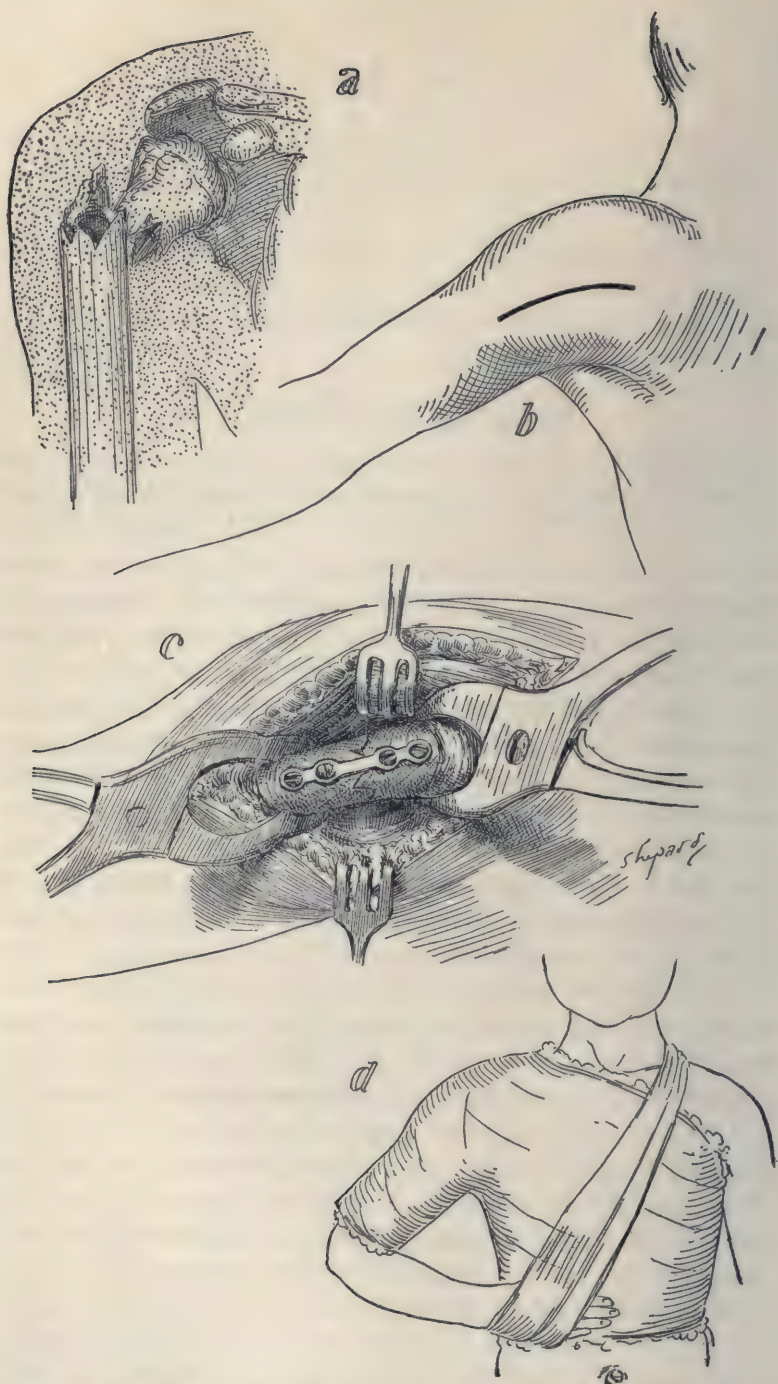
Fracture of upper end of humerus: *a*, x-Ray appearance of fracture; *b*, line of incision; *c*, application of Lane plate; *d*, final dressing.
